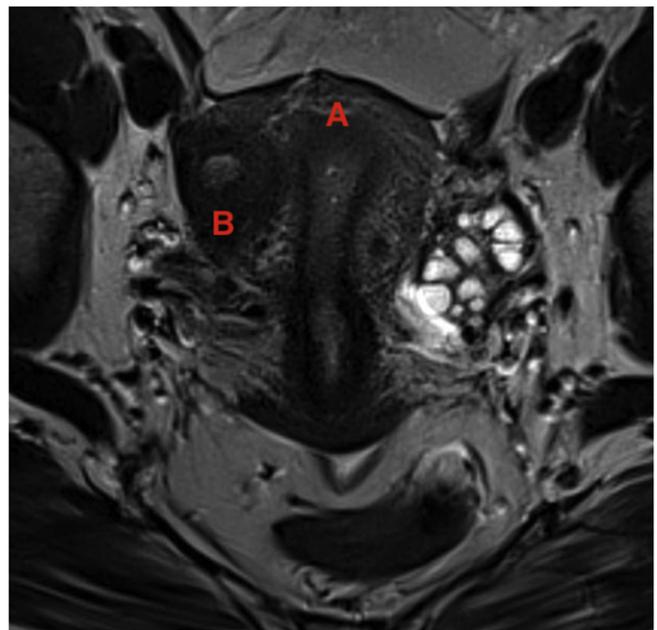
MRI in frontal section in T2 sequence: A: uterus with hypersignal T2; B: right lateral-uterine mass not communicating with the endometrial cavity.
